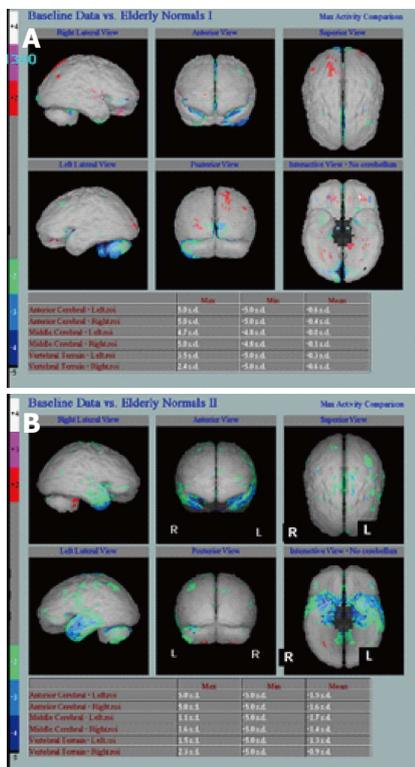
Underlying neuronal dysfunction and neurodegeneration. A: Hexamethylpropylene amine oxime (HMPAO) single photon emission computed tomography (SPECT) in normal subject demonstrating normal almost symmetrical perfusion pattern; B: HMPAO SPECT in Alzheimer's disease parametric images demonstrate bilateral reduction in perfusion in the temporal lobes especially in the medial temporal regions up to 2 (green) and 3 (blue) standard deviation (Images kindly prepared by Ms Lesley Lovell, Senior technician).
